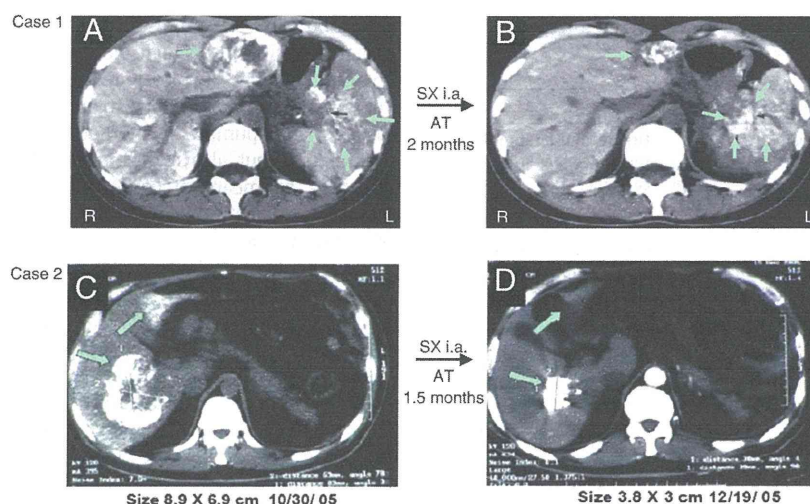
Cases 1 and 2. Therapeutic effect of SMANCS/Lipiodol against advanced, difficult-to-treat cancers. The drug was infused via the tumor-feeding artery (hepatic artery) under angiotensin II-induced high blood pressure. A and C are abdominal CT scans 2 days after drug infusion. B and D are CT scans taken 2 and 1.5 months after drug infusion, respectively. Case 1. Pancreatic cancer with metastatic liver cancer (A) regressed significantly after 2 months. (B) Remarkable reduction in the size of the metastatic liver cancer (top, right). Case 2. Gastric cancer had metastasized to the liver (C). The two visible large tumor foci evidenced a marked size reduction after 1.5 months (D). White areas in the CT scans, other than bones, indicate where SMANCS/Lipiodol was selectively taken up by the tumors; other (normal) areas did not take up the drug (see the text for a description of the procedure). From Ref. [25].
